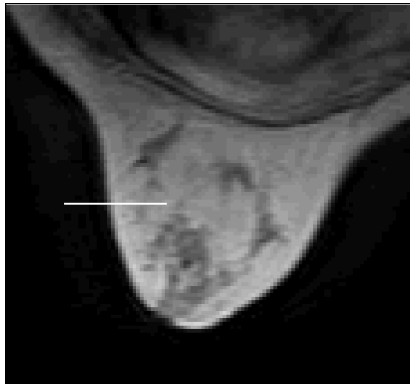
A typical MRI image. The effect of the bias field is clearly apparent as a signal decrease towards the chest wall. The breast is almost entirely fat, so the breast tissue is constant and the MR signal intensity should ideally also be constant; the intensity variation along the line  $AB$ , however, shows a 60% signal attenuation through the breast.
